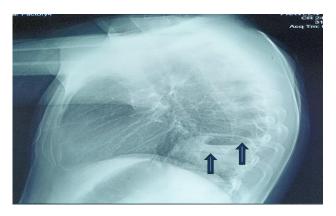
Lateral view of chest radiograph showing a large cavity lesion in the left lower zone with air containing membranous structure capped by air crescent – the 'cumbo sign'.
